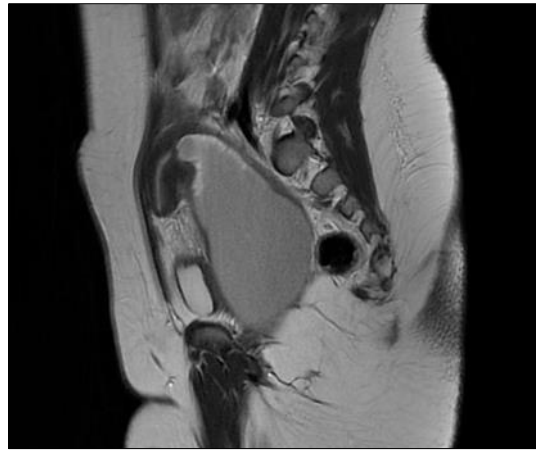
MRI showing the haematocolpos of the obstructed right hemivagina and the ipsilateral hemiuterus on the top
